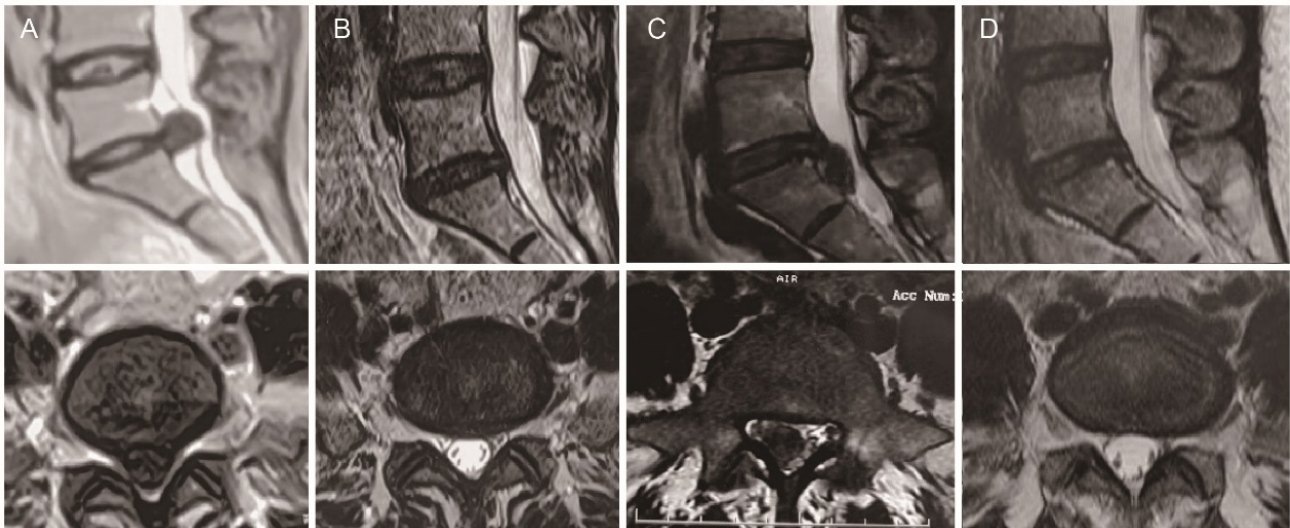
Sagittal and axial MRI scans demonstrating resorption of herniation at 3-month follow-up. (A) Baseline MRI. (B) MRI at 3-month follow-up. (C) Baseline MRI. (D) MRI at 3-month follow-up. MRI=magnetic resonance imaging.
